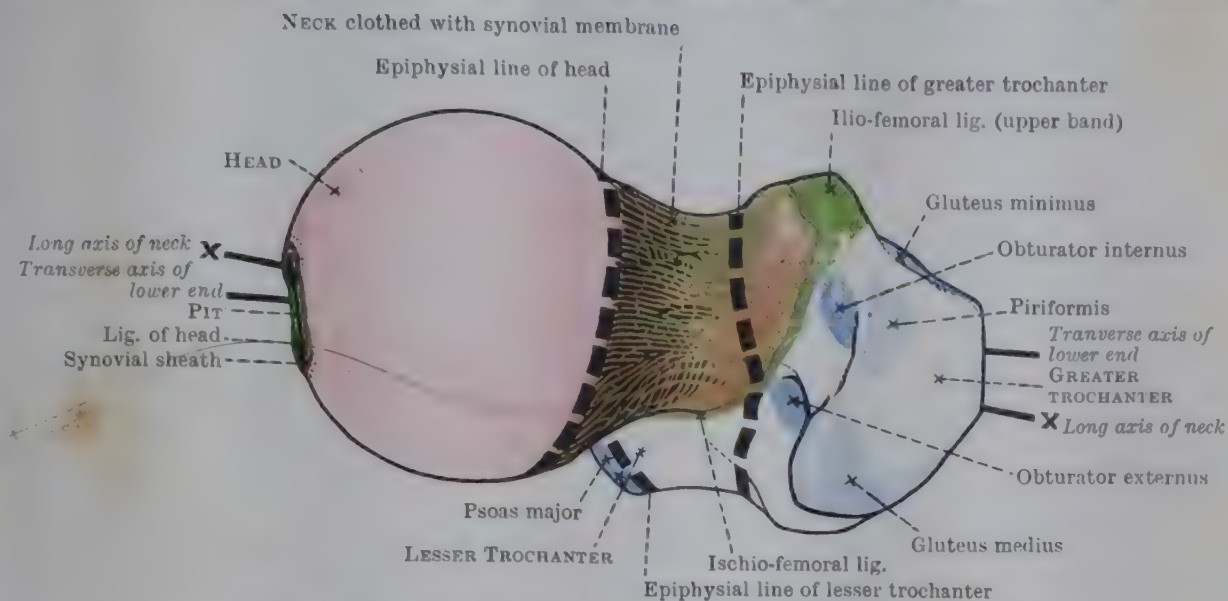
UPPER ASPECT OF UPPER END OF RIGHT FEMUR.
